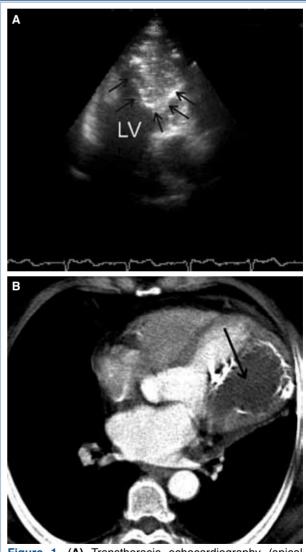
(A) Transthoracic echocardiography (apical 2-chamber long-axis view) shows a mass appearance (arrows) with heterogeneous echogenicity. (B) Computed tomographic view shows a lesion (arrow) 50x65 mm in transverse diameter suggesting a calcified left ventricular aneurysm.
